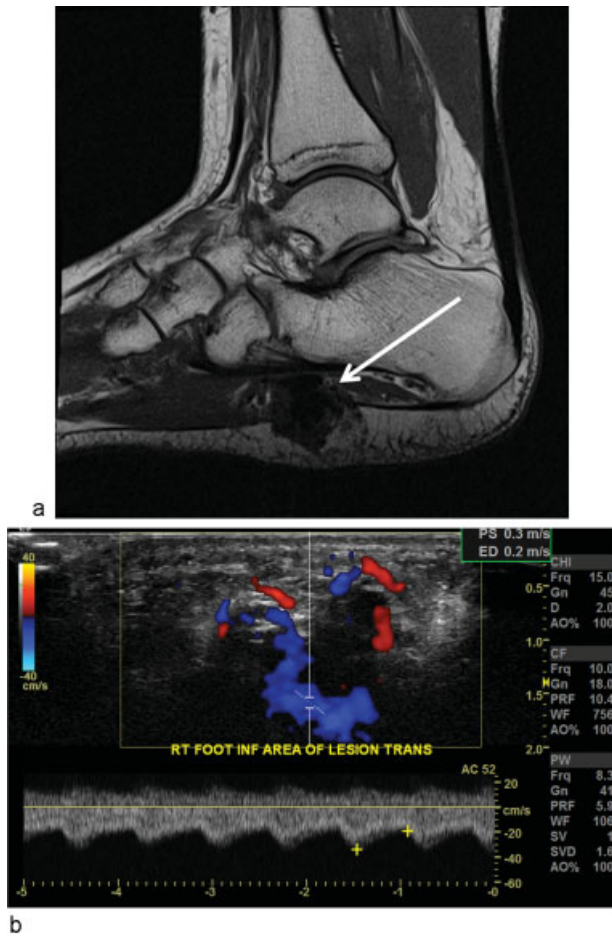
Noninvasive imaging of the right foot abnormality. (a) Sagittal T1-weighted MRI image shows round lesion with flow voids on the sole of the foot (white arrow). (b) Doppler ultrasound of the lesion shows arterial waveforms.
